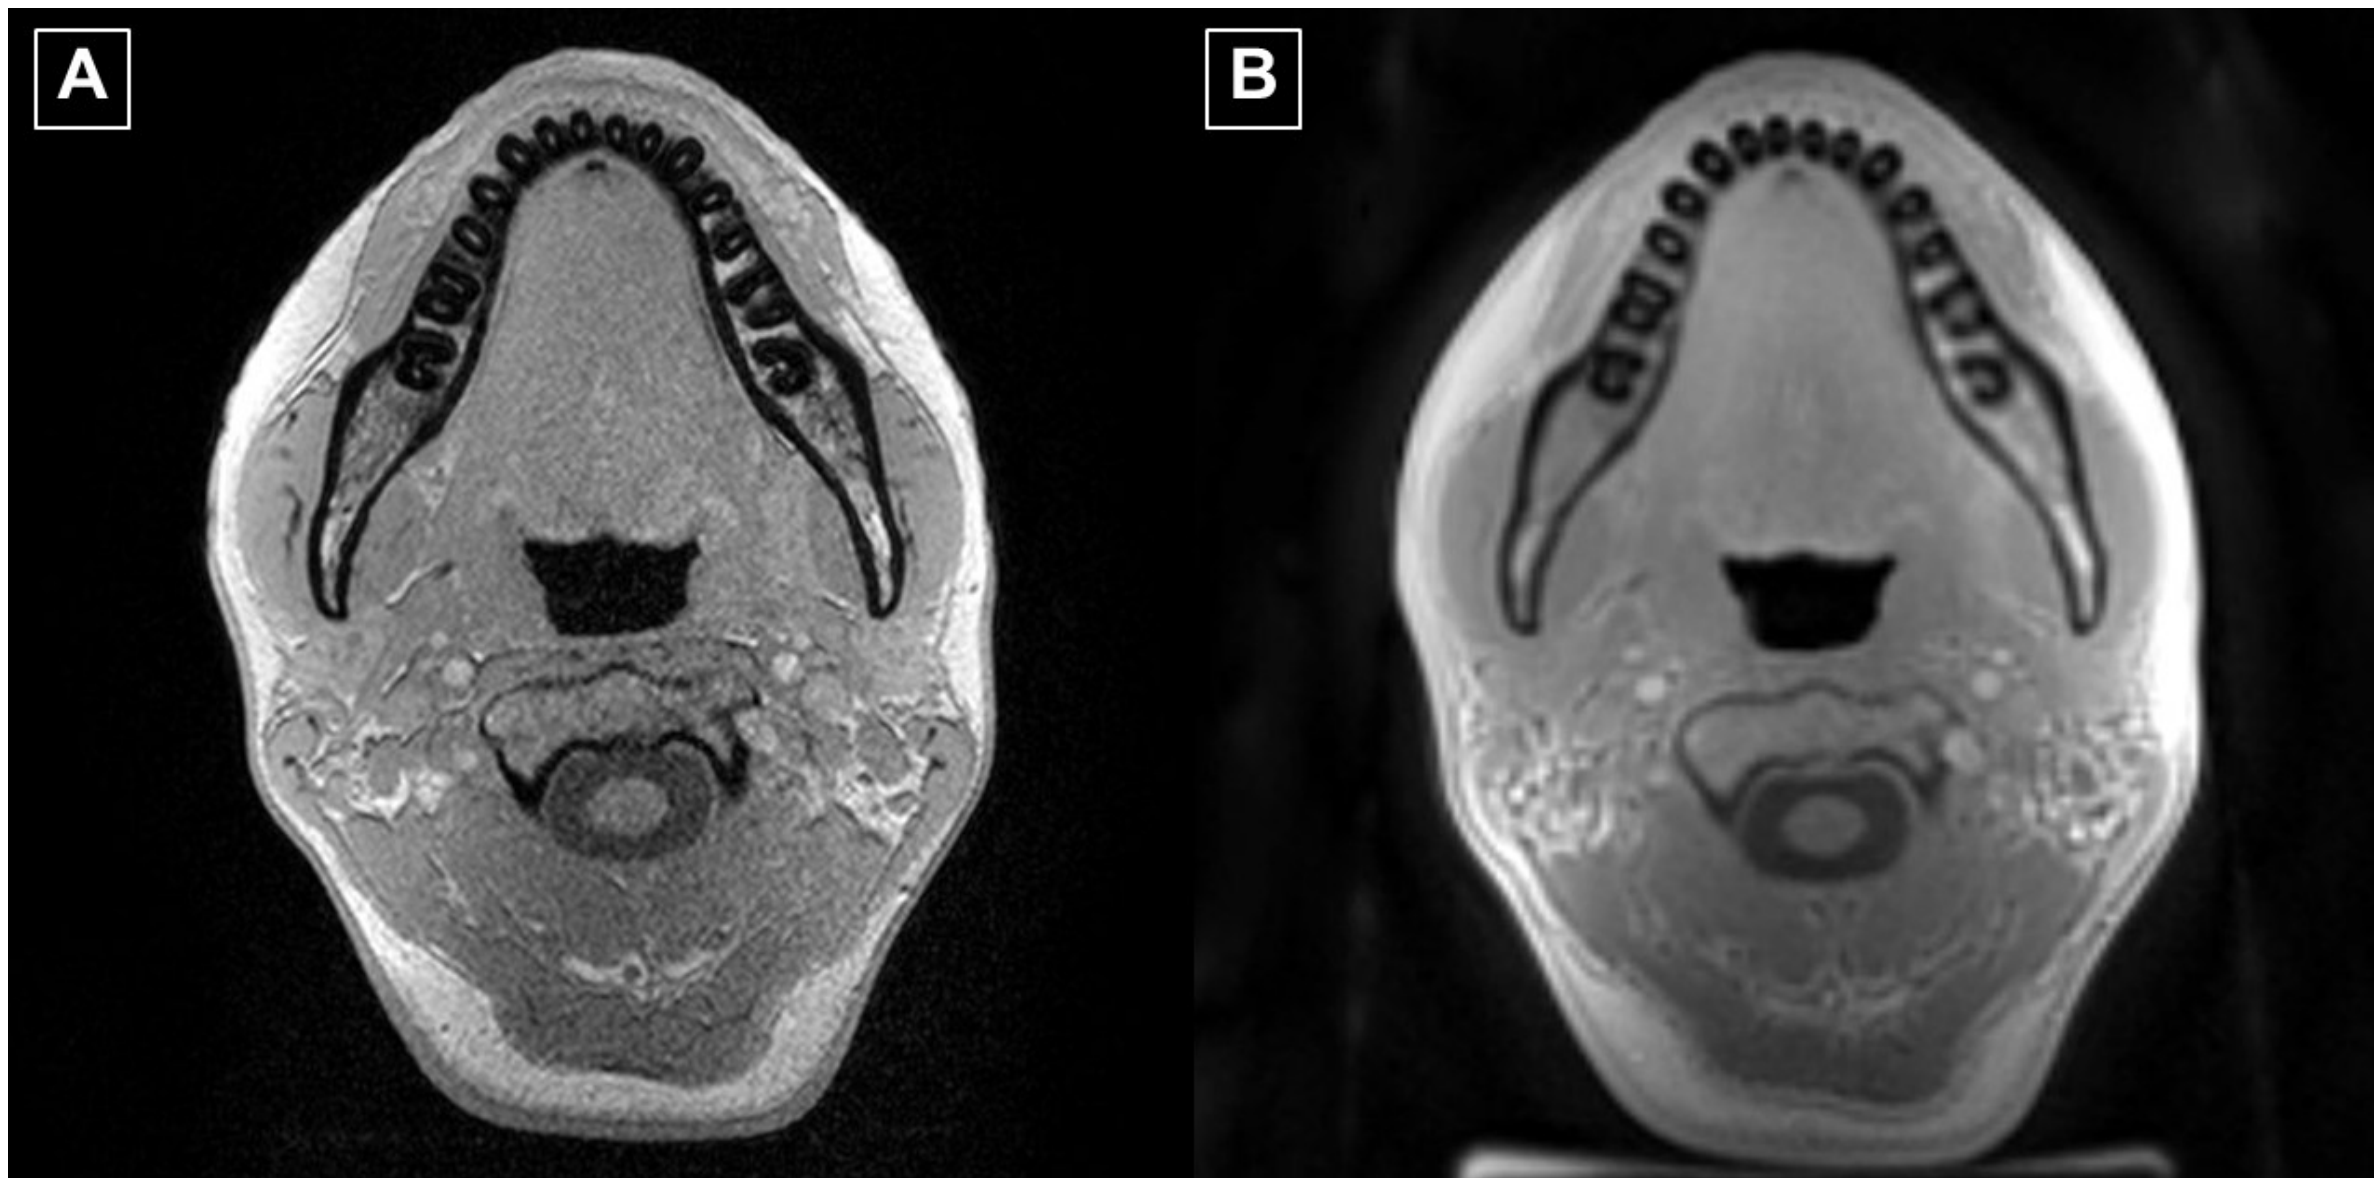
Volunteer imaging, showing (A) black bone and (B) UTE MRI.
